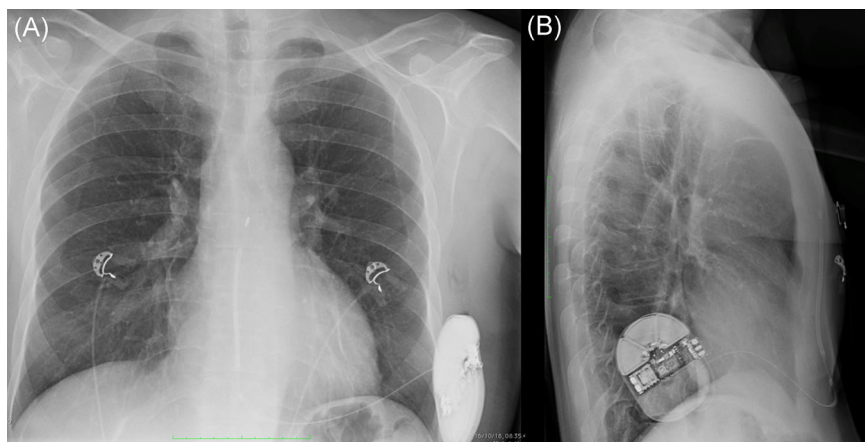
Chest X-ray anteroposterior view (A), and lateral view (B) after S-ICD implantation using the intermuscular two-incision technique. Note the virtual space between the pulse generator and the posterior placement (dorsal) of the device that may provide an improved vector toward the shocking coil capturing more left ventricular mass compared with the conventional subcutaneous approach
